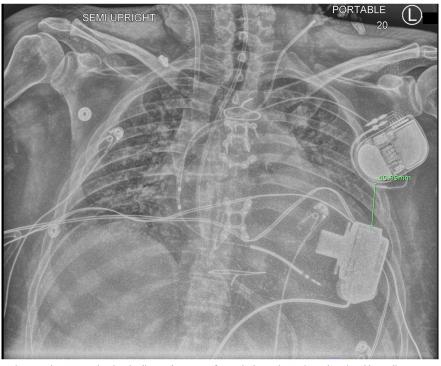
Chest X-Ray showing the distance between Left Ventricular Assist Device and Implantable Cardioverter Defibrillator before extending patient's left arm.
